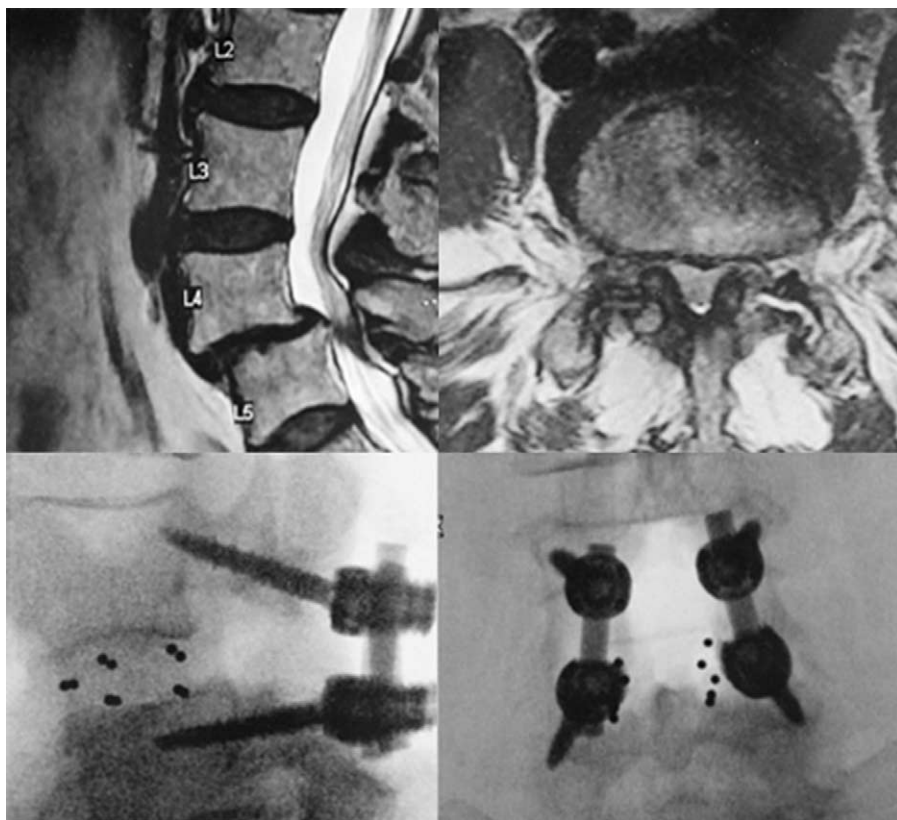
Magnetic resonance imaging (MRI) and fluororadiographs showing treatment of L4–5 degenerative spondylolisthesis with MAS PLIF.
